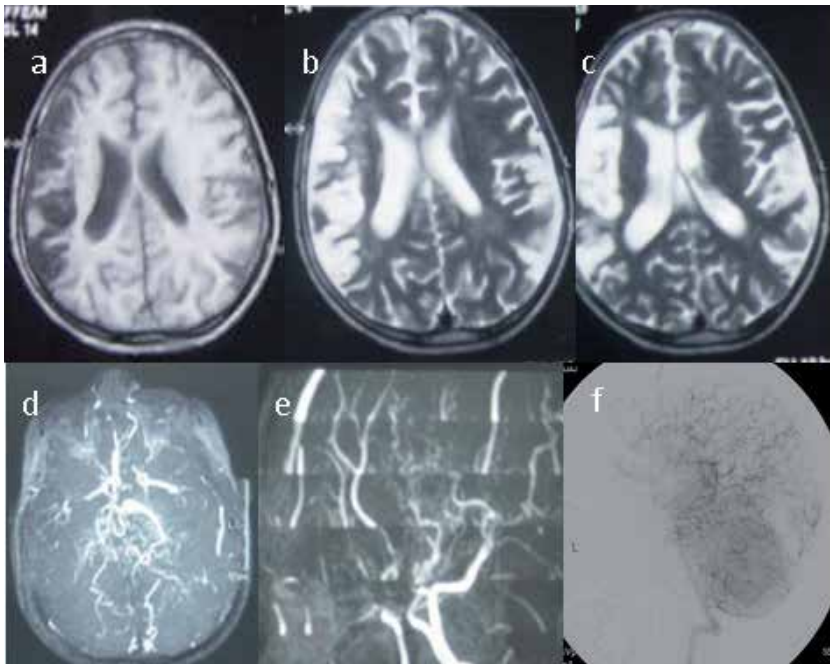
Neuroimaging of a young boy of 6 years of age who presented with recurrent ischemic strokes. MRI brain axial sections show altered signal intensity areas hypointense on T1 (a) and hyperintense on T2 (b, c) in bilateral frontoparietal cortex involving the MCA territory. Angiographic images show multiple tortuous collaterals involving both anterior (d) and posterior circulation (e, f) giving the typical “puff of smoke” appearance on cerebral DSA (f).
